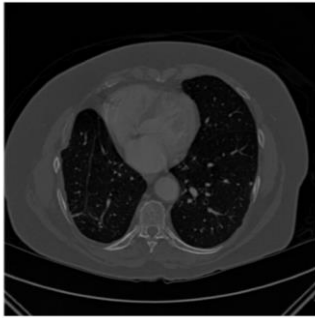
Original CT image
